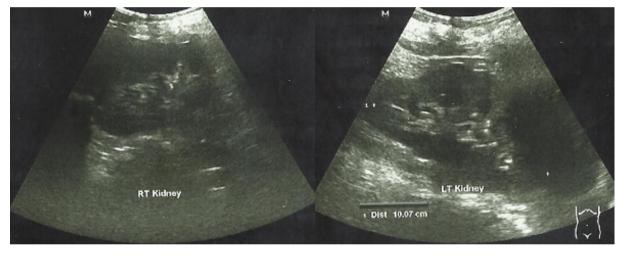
Renal ultrasonography of the patient at 2 weeks after admission
